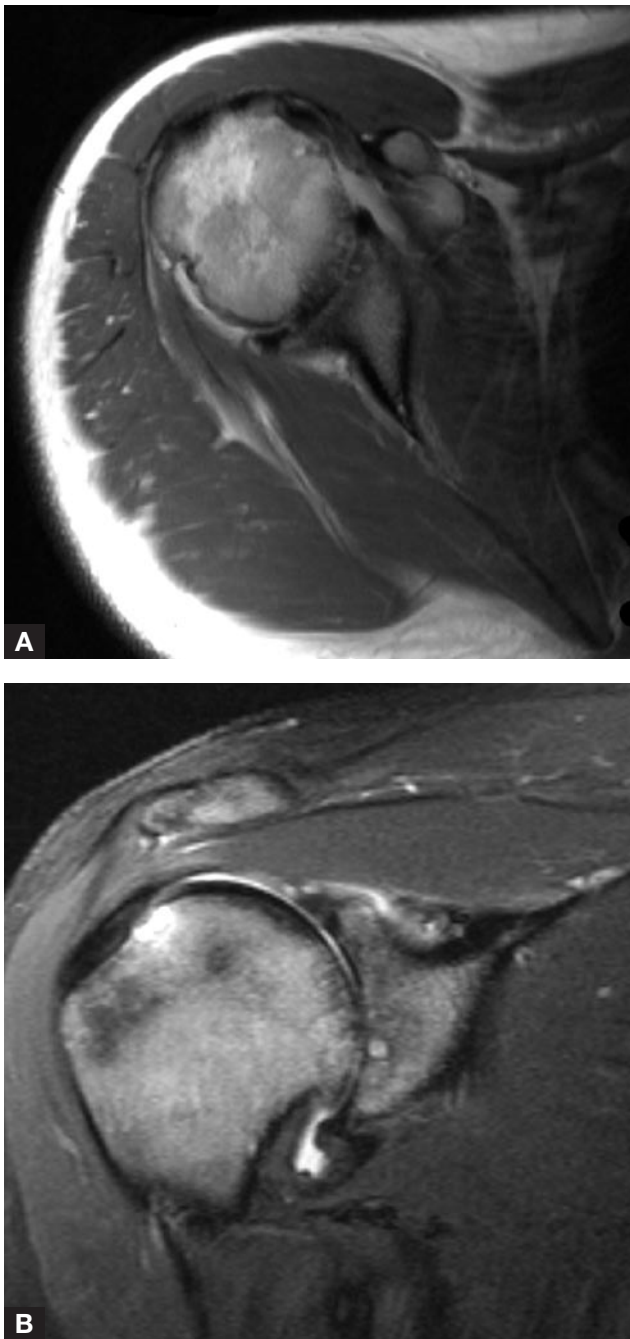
Case 1: (A) Axial magnetic resonance imaging (MRI) of right glenohumeral joint shows significant arthritis in a woman in her early 20s after thermal capsulorrhaphy. (B) Coronal MRI of right glenohumeral joint shows significant arthritis.
